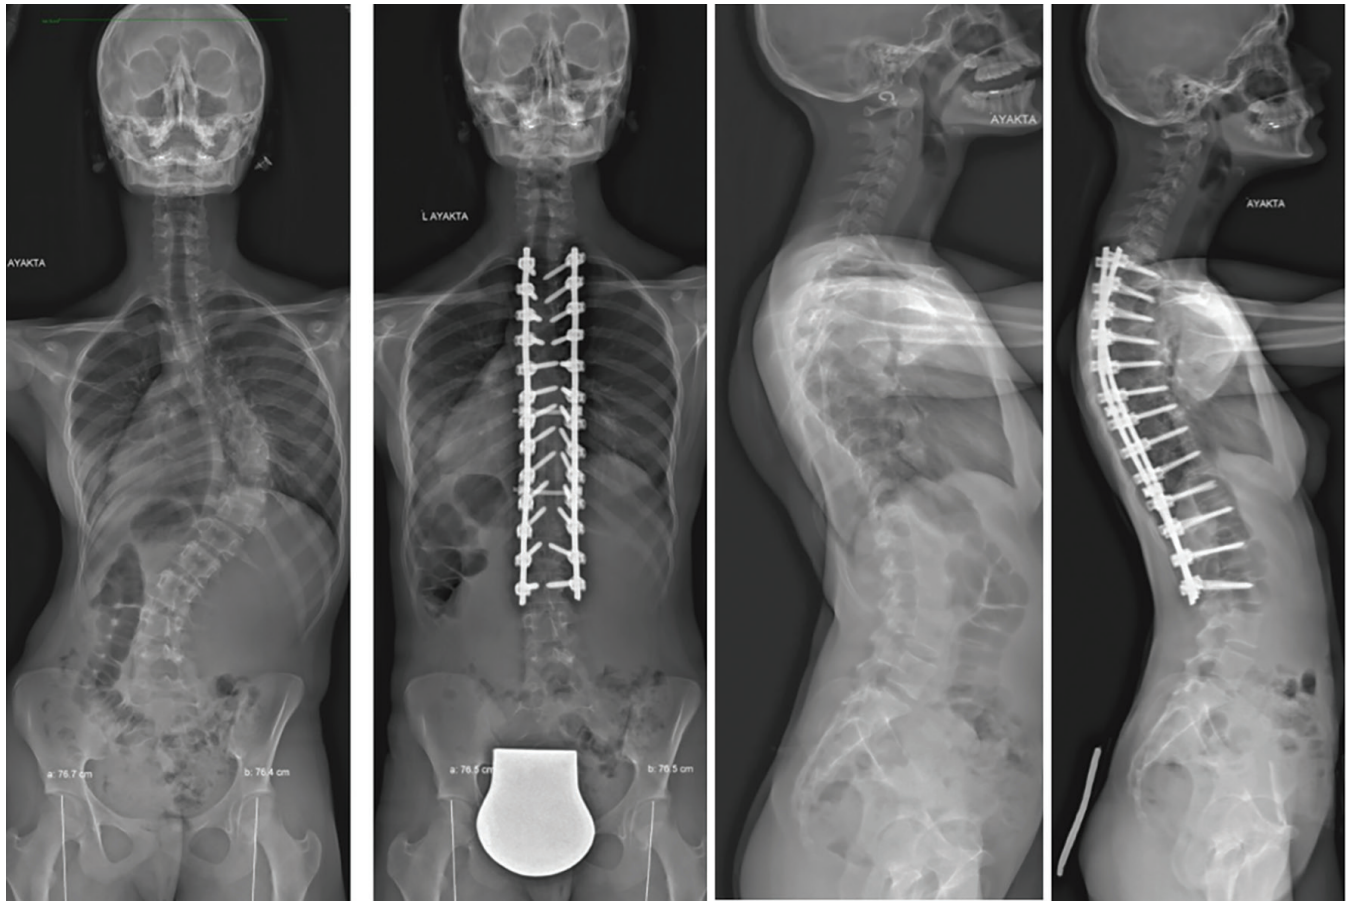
Pre- and postoperative standing whole-spine anteroposterior and lateral radiographs of a 15-year-old girl with adolescent idiopathic scoliosis treated with posterior pedicle-screw instrumentation
